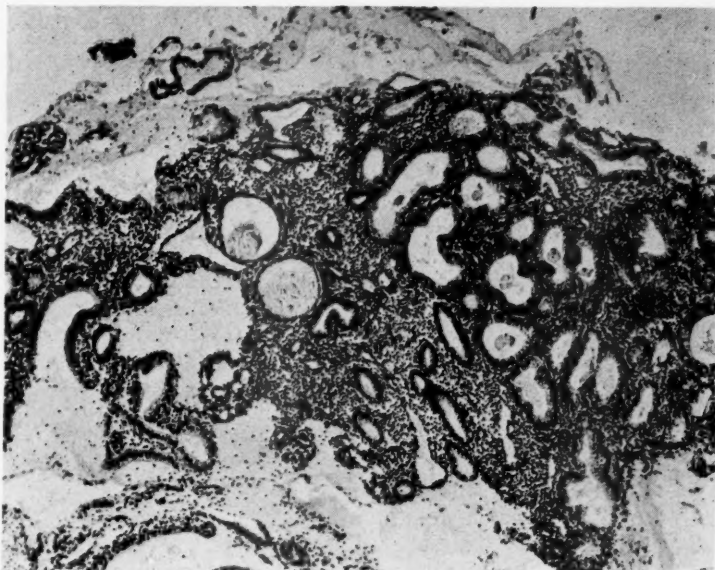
Very mild hyperplasia, not of typical Swiss-cheese type, and not at all suspicious of malignancy, in woman 55 years of age, treated with curettage and x-ray.
